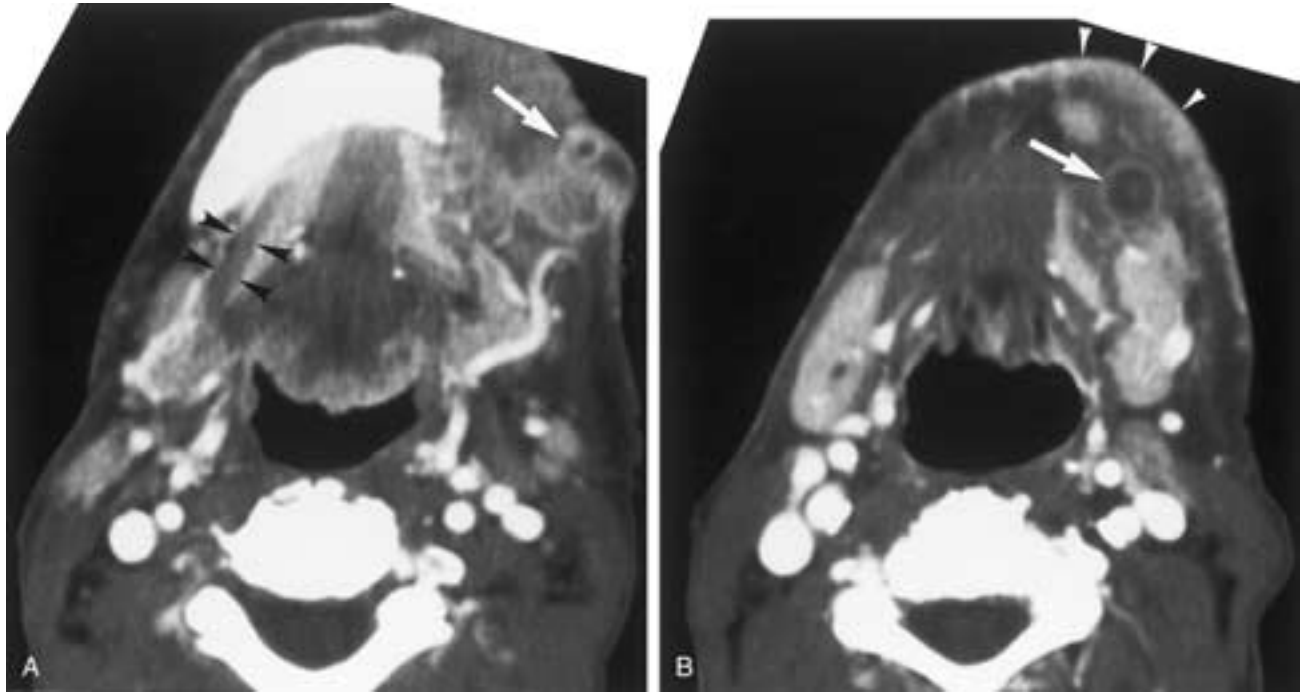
Squamous cell carcinoma probably arising from the gingiva-buccal mucosa. A, and B, Axial contrast-enhanced CT scans reveal a large tumor on the left, extending to the skin, destroying the left portion of the mandible, and invading the left mylohyoid muscle. Fibers of the right mylohyoid muscle are well defined (*black arrowheads in A*). Metastatic disease to the left submandibular nodes is also identified (*white arrows in A and B*). Thickening and involvement of the skin are easily seen (*white arrowheads in B*).
